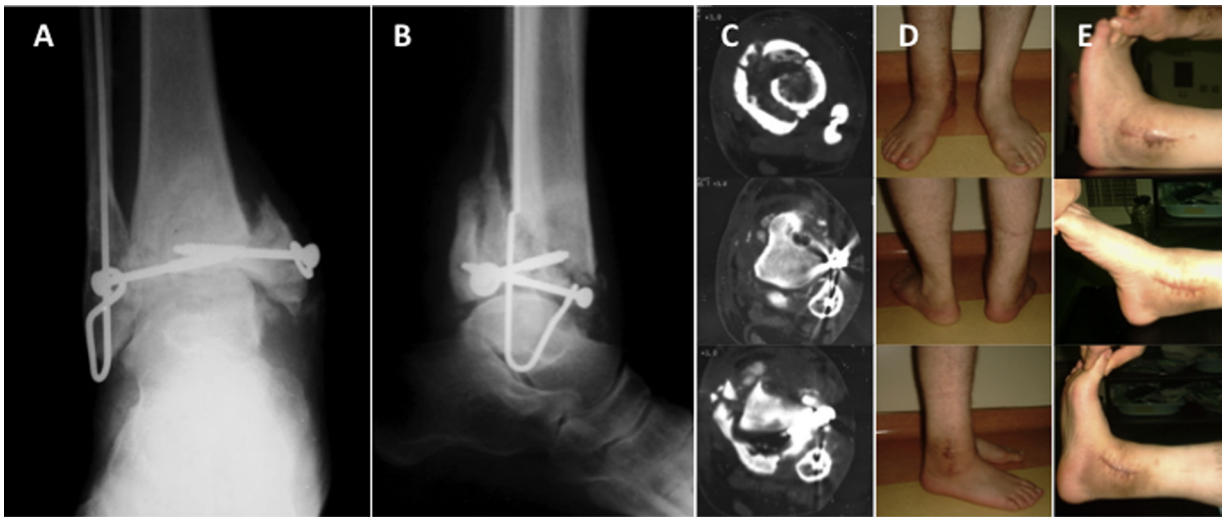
Assessment of ankle joint; (A, B) anterior–posterior and lateral radiographs, showing implant failure, pseudarthrosis and joint destruction; (C) CT image; and (D, E) weight bearing and ankle movements after initial surgery.
